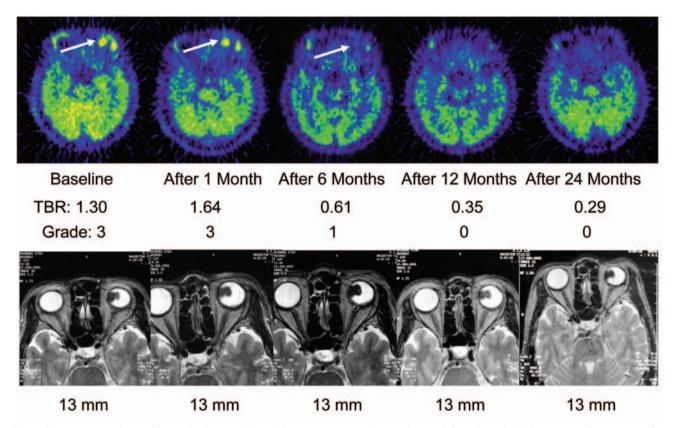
MET-PET and MRI T2 weighted image of Case 14. Tumor size was almost unchanged throughout the follow-up term, but MET uptake disappeared after 12 months. This patient has shown no regrowth so far. Arrow: melanoma lesion.
